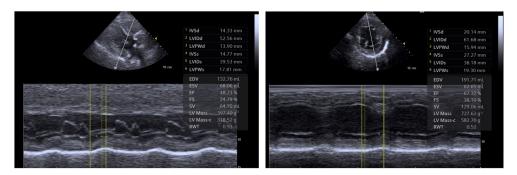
Figure nr. a.2.1 Concentric LV hypertrophy evaluated in M-mode in two different views: left-parasternal long axis (LVmass-i=318 g; RWT=0.53); right-parasternal short axis (LVmass-i=582 g; RWT=0.52);
